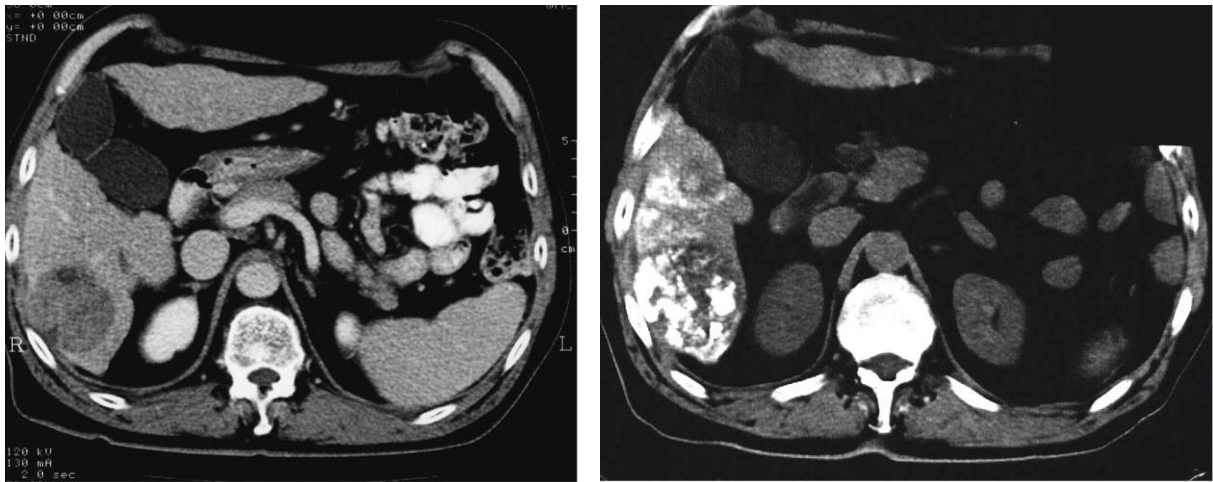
a) HCC located in the right lobe, 6th segment: contrast-enhanced CT; b) Non-enhanced CT follow-up at 48 hours post-embolization: concentration of lipiodol emulsion predominantly in tumor, with delimitation of adjacent daughter nodules.
